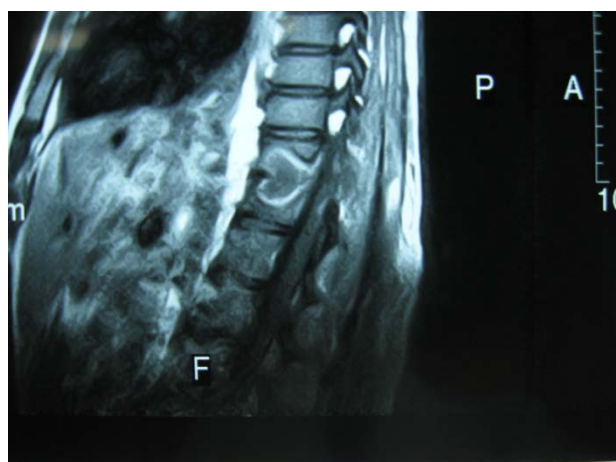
Mid-sagittal Enhanced T1W MRI showing ring enhancement of the above Spondylo-discitis affecting two contiguous vertebrae of Spondylo-discitis
